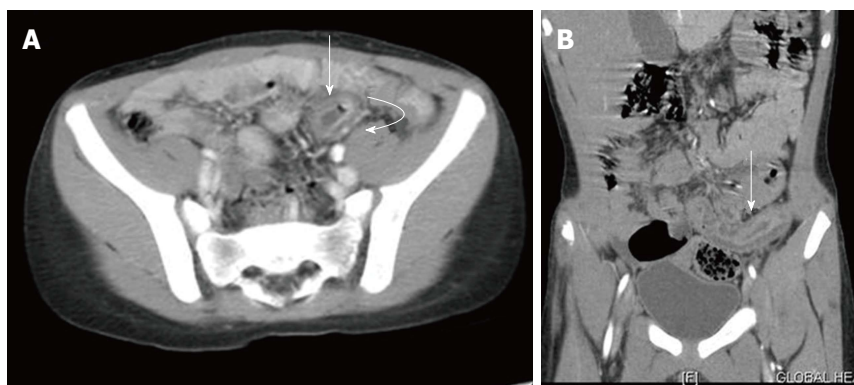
Bowel involvement in Henoch-Schonlein purpura in an 8-year-old child. A: Axial contrast-enhanced computed tomography image shows circumferential wall thickening in a mid-ileal loop with target like appearance (straight arrow) with adjacent engorged mesenteric vessels (curved arrow); B: Coronal reformatted images shows long segment thickening of the mid-ileal loop (straight arrow).
